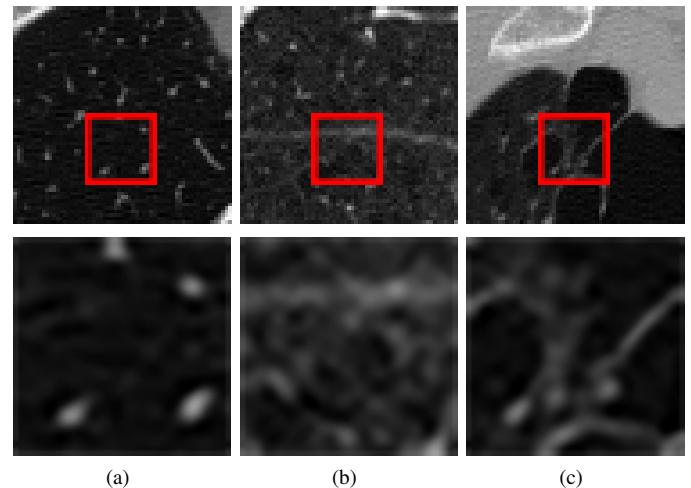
First row shows lung tissue ROIs from the computed tomography emphysema database [6]. Second row shows red squares drawn and magnified by a factor of 4. (a) NT; (b) CL; and (c) PS.
